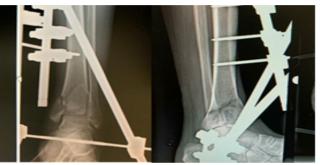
IMMEDIATE POST OP XRAYS
